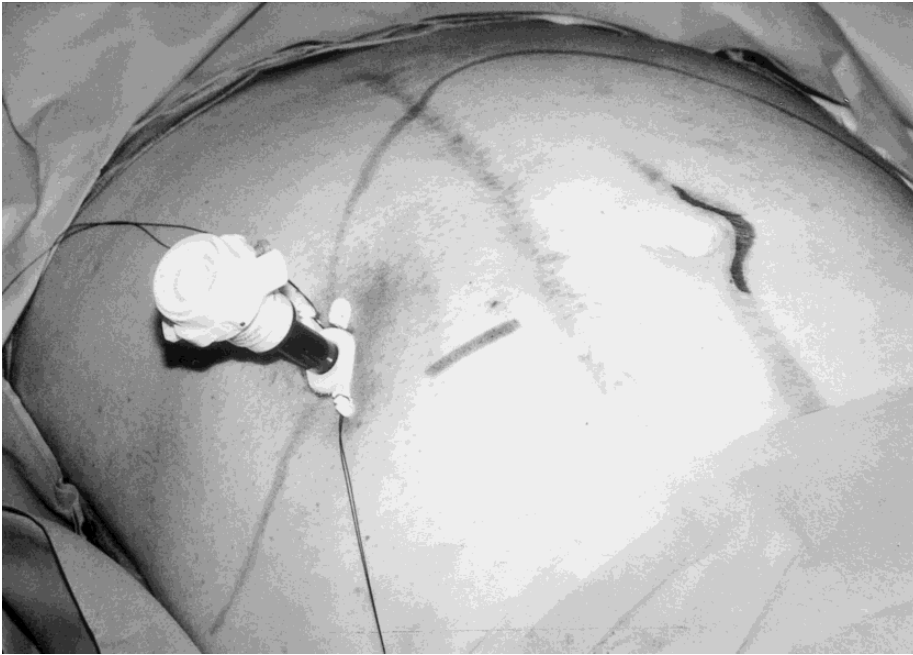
Incision options for open diagnostic laparoscopy in the previously operated abdomen, with consideration of access to the liver for intraoperative laparoscopic ultrasound. In this instance, right upper quadrant entry was chosen because of the obvious periumbilical incisions.
